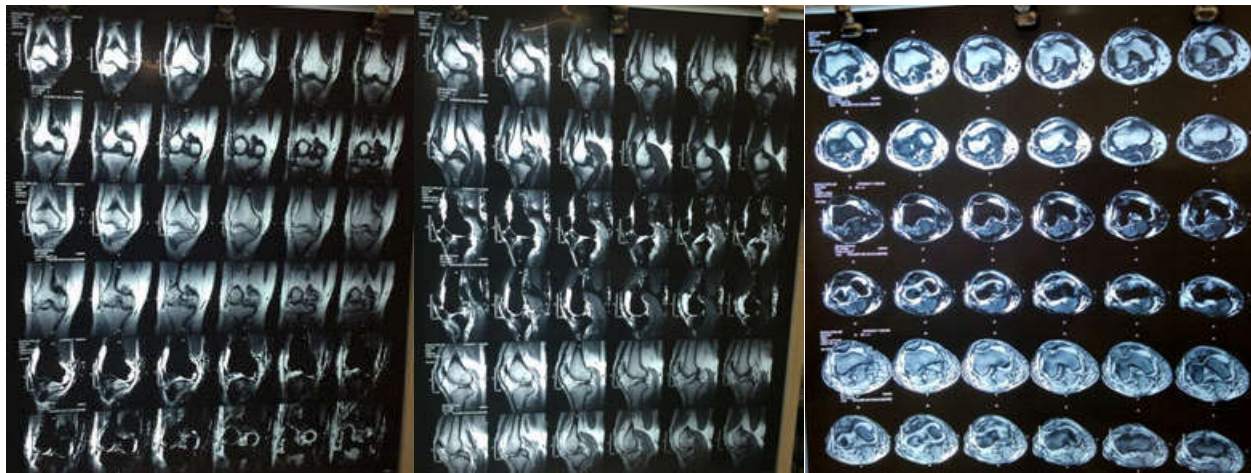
Pre-Op MRI of Right Knee
